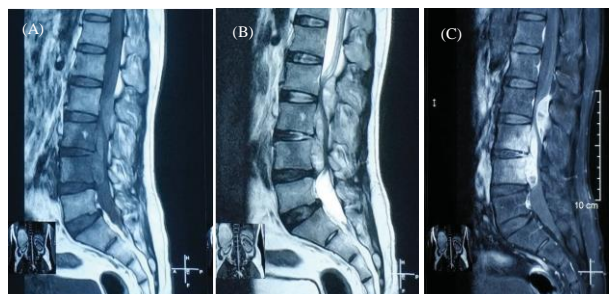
MRI Sagittal view showing an epidural mass which was occupying post aspect of spinal cord at L2, anterior aspect at L3,4 level; seen as isointense on T1WI (A) and hyperintense on T2WI (B) and heterogeneous enhancement on post contrast film (C). More than half of the L3,4 vertebral body had shown involvement by the lesion.
